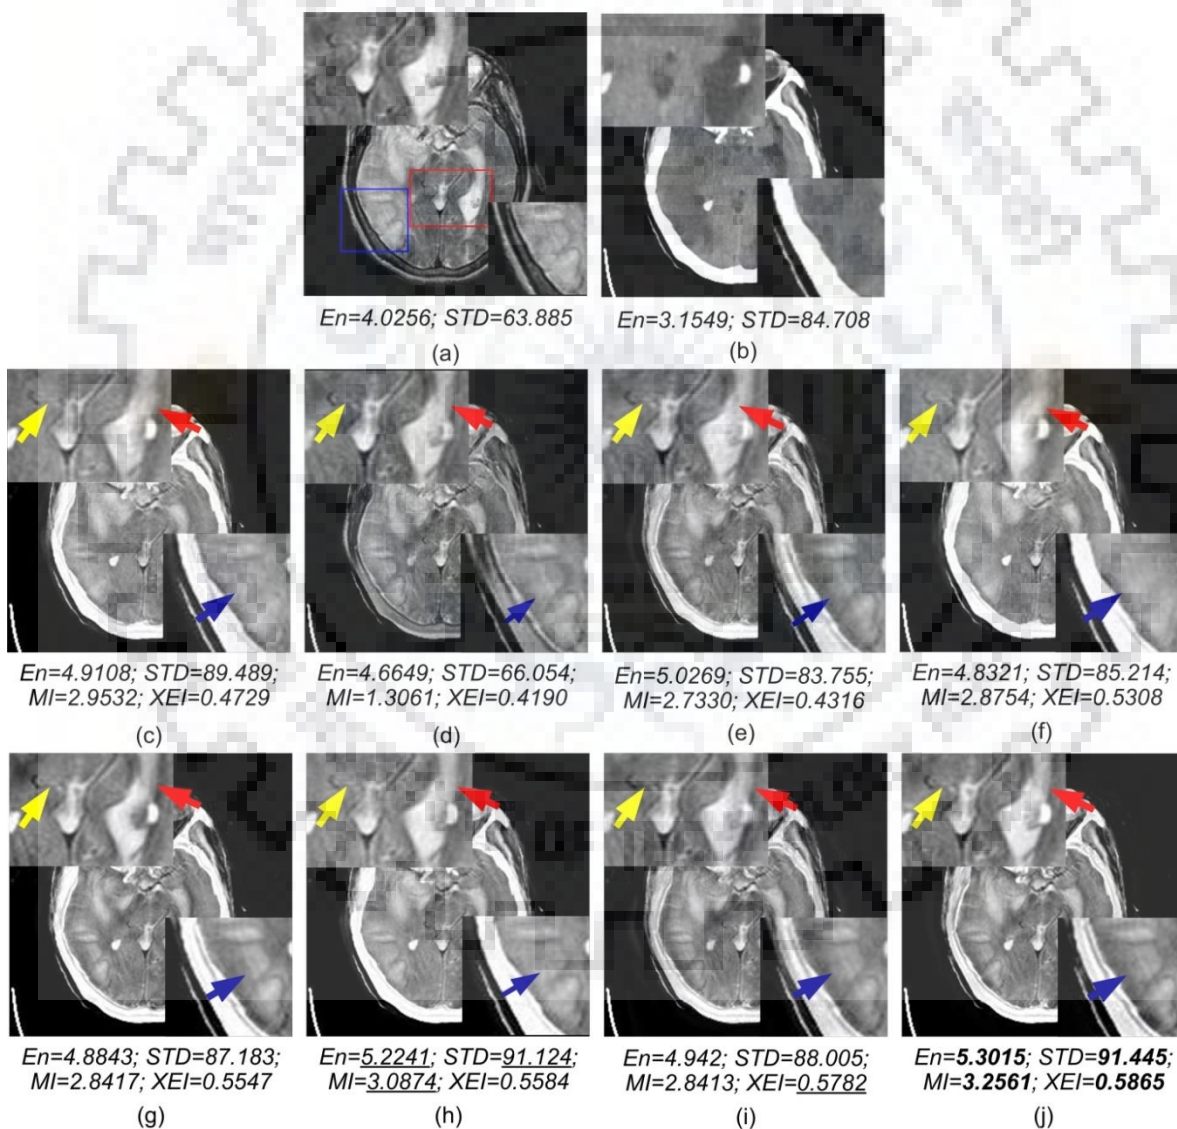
(a) MR images with two zoom regions marked by red and blue color (b) CT image, fused images along with the corresponding zoomed regions obtained by (c) Das and Kundu, 2012 [34] (d) Li et al. (GFF), 2013 [94] (e) Liu et al. (MST-SR), 2015 [109] (f) Ganasala and Kumar, 2016 [48] (g) Yang et al., 2017 [203] (h) C-MIF method (i) Yang et al. (NSCT-Type 2 Fuzzy), 2016 [201] (j) Proposed SDL-MIF method
